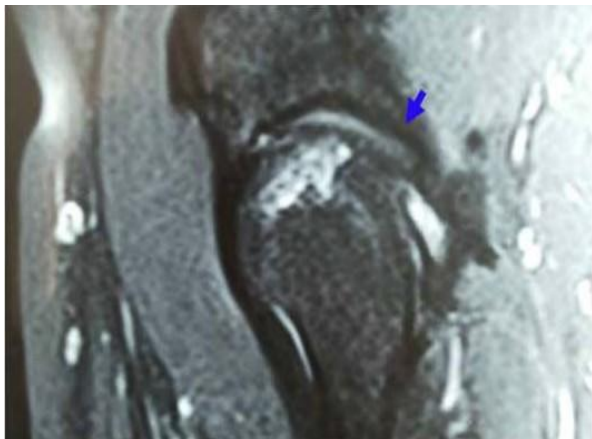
Case 3: Loss of cartilage as shown by MRI. The complete loss of joint hip bone cartilage in the femur head is shown by this MRI at the diagnosis stage and prior to the decision to perform and subject the patients to the stem cell and platelet rich plasma therapies. Comparison of this MRI to Figures 5B and 5C post SCT + PRPT show the marked contrast in the cartilage development. Blue arrow shows the cartilage location in the cartigram.
